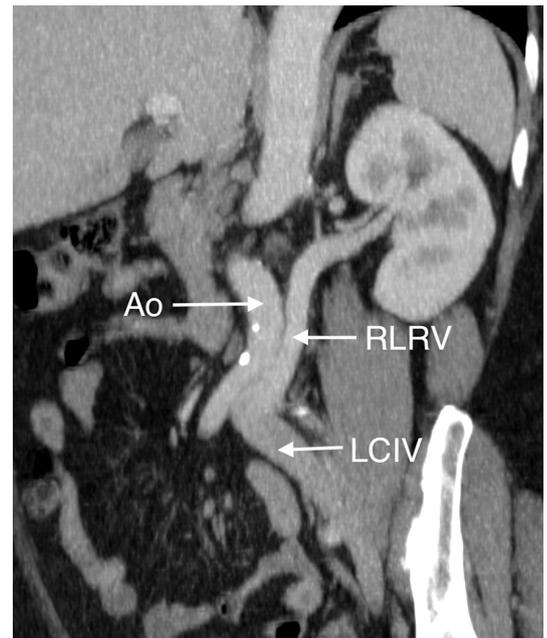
Oblique, coronal, curved multiplanar reformatted, intravenous contrast enhanced, MIP CT image (mixed arterial/venous phase), showing the RLRV located oblique and posterior to the Ao and draining into the LCIV. Ao, abdominal aorta; LCIV, left common iliac vein; MIP, maximum intensity projection; RLRV, retroaortic left renal vein.
